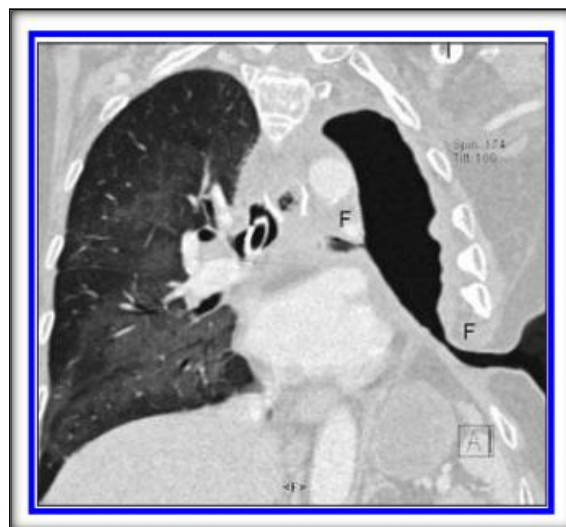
Coronal reconstruction CT image of thorax shows bronchopleural cutaneous fistulas (F)
